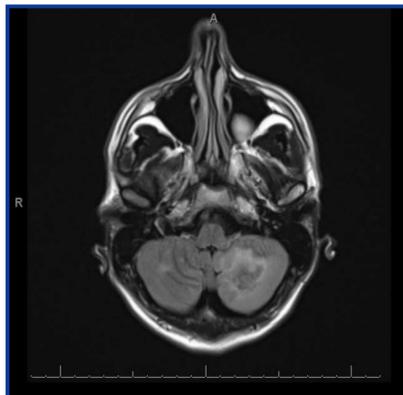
(left): Left cerebellar lesion with high signal intensity on T2-weighted and fluid attenuated inversion recovery (FLAIR) sequence
